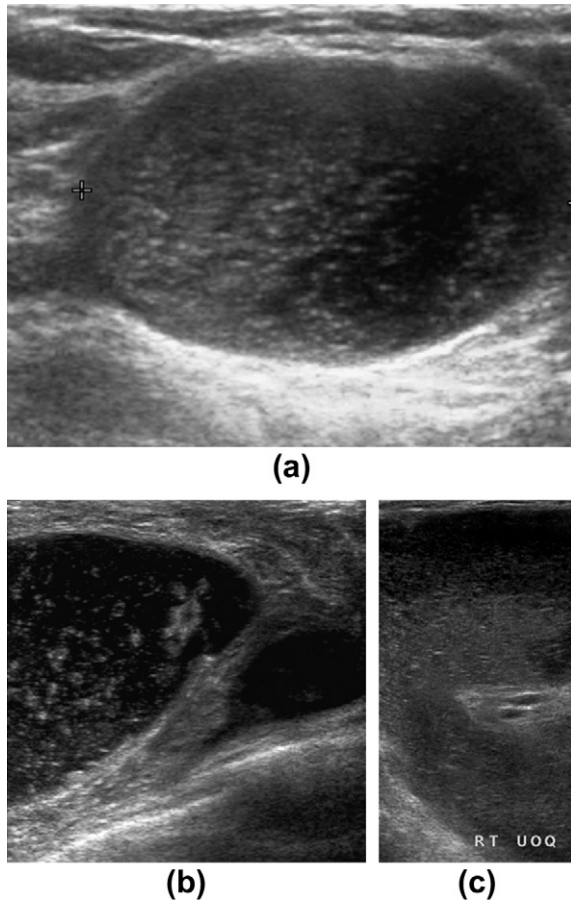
(a–b) “Sparkly lake” sign — largely anechoic areas containing multiple internal echoes of varying size and echogenicity are typical of uncomplicated Macrolane collections on ultrasound. This has to be differentiated from more sinister pathology such as an abscess, as demonstrated in (c).
